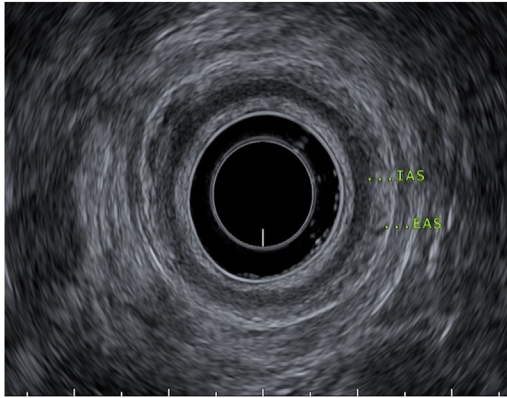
Endosonographic appearance of the normal internal and external anal sphincters.
